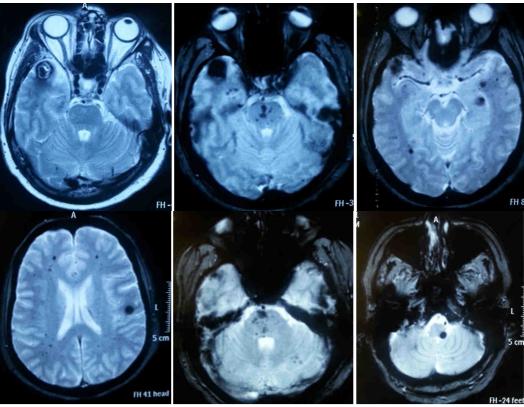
Echo gradient MRI sequence showing multiple cavernomas the biggest of the in the right temporal pole. Many small cavernomas are located in the brain stem
